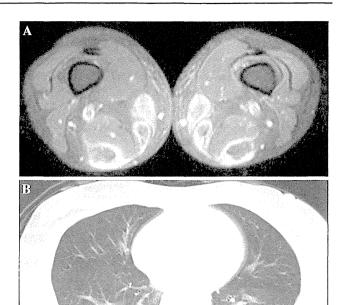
a Magnetic resonance imaging (short tau inversion recovery, STIR) of the thigh. Note the symmetric inflammation in the affected muscle and fascia, seen as bright areas. b Chest CT imaging. Note the bilateral ground-glass attenuation with reticular opacity
